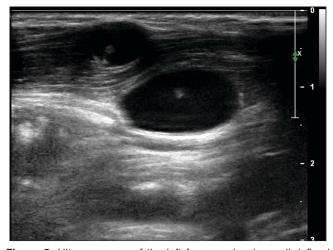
Ultrasonogram of the left forearm showing well-defined cystic lesions
